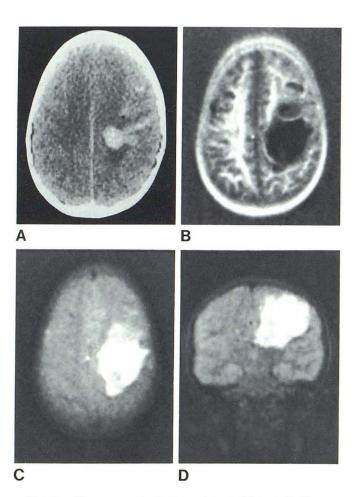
Fibrosarcoma. A, Contrast-enhanced CT scan. B, $IR_{1400/400}$ NMR scan. Mass displays long T_1 and internal structure. Transverse (C) and coronal (D) $SE_{1160/80}$ NMR scans show extensive surrounding edema.
